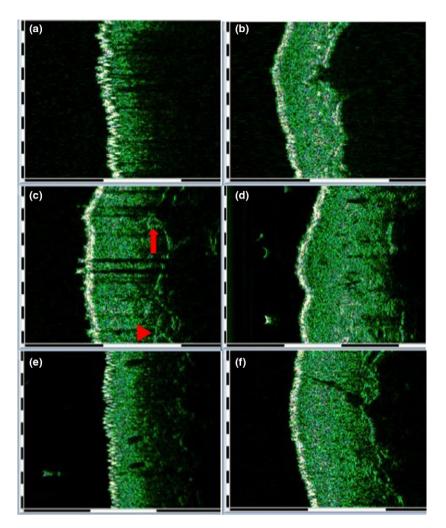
(a–f) Ultrasonography (50 MHz) images of generalized plaque morphoea (GPM) and deep morphoea (DM) compared with healthy skin. (a) Unaffected skin at baseline in a patient affected by GPM; (b) unaffected skin in a patient with DM; (c) a representative sclerotic area of GPM before therapy, showing dermal undulation (sharp arrow) and yoyo figures (thick arrow); (d) ultrasonographic assessment of DM before therapy, showing absence of dermal undulation and increase in dermal thickness; (e) generalized plaque morphoea lesion after therapy, showing an increase in echogenicity and homogenization of the dermis; and (f) DM after therapy, showing a partial (although not statistically significant) reduction in dermal thickness.
